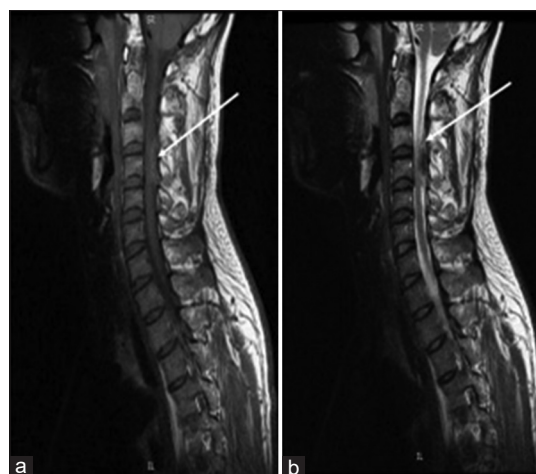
(a) The T1-weighted images showed an isointense, dorsolaterally situated epidural collection on the left side extending from C4 to C6. (b) The T2-weighted images displayed a heterogeneous signal within the lesion
